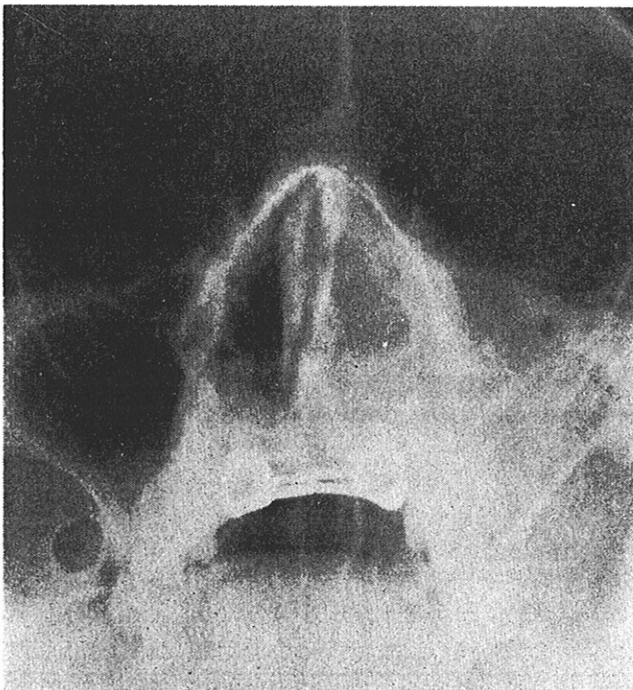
Case 7. Paranasal sinus X-ray (occipitomeatal view) showing opacification of left maxillary sinus with erosion of the lateral nasal wall. Normal right maxillary sinus.
